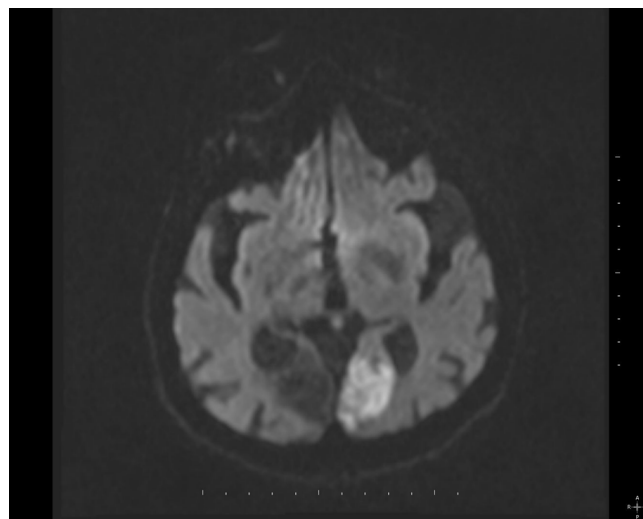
In diffusion magnetic resonance imaging, restriction of diffusion in the medial part of the left occipital lobe in accordance with acute infarction
